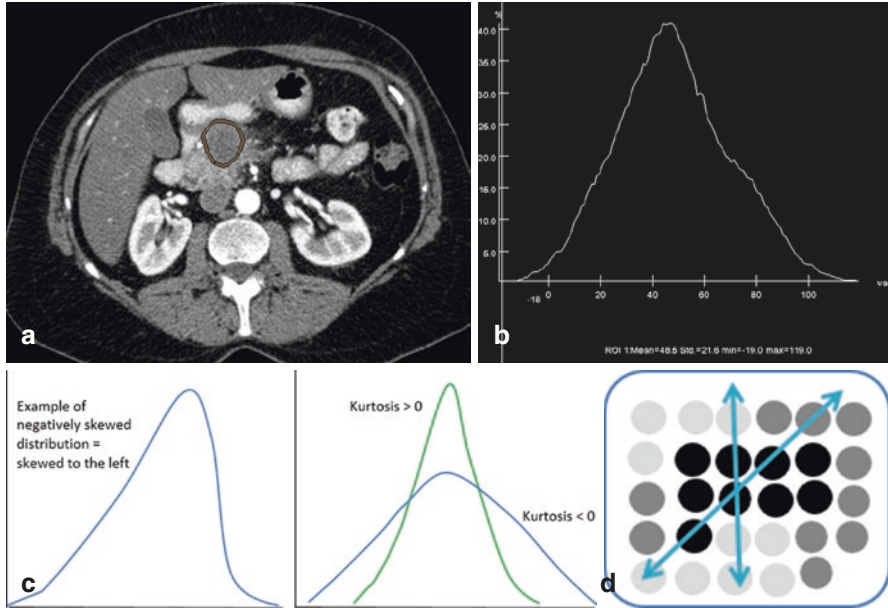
(a–d) Principles of CT texture analysis
